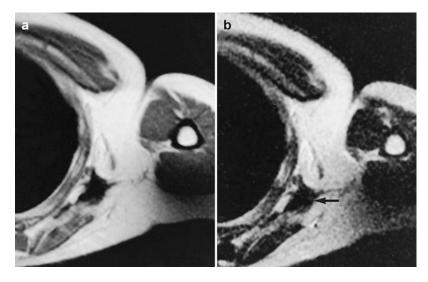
(a, b) Malignant soft tissue tumor studied after surgery and radiotherapy in a 30-year-old male: (a) axial T2-weighted MR image shows low signal intensity
